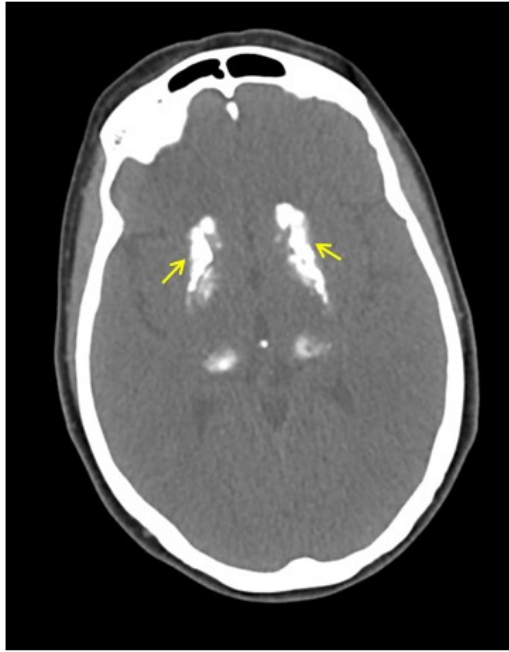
Brain computed tomography of a patient with IBGC showing bilateral calcification (arrows) of the basal ganglia.
